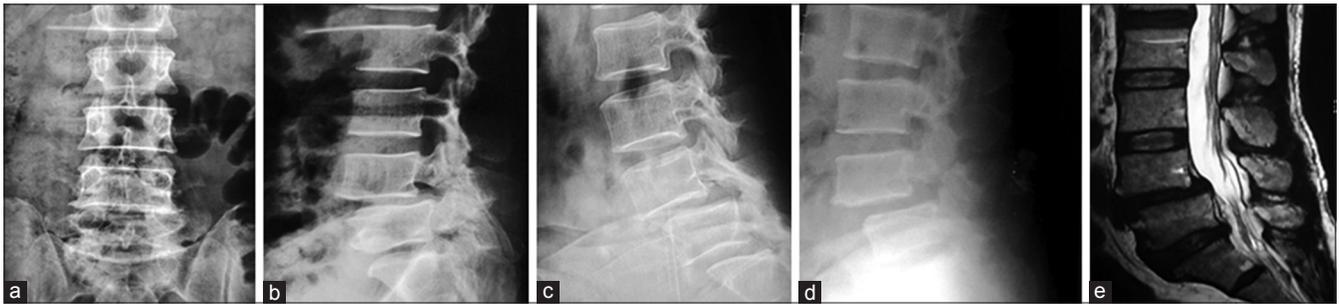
Degenerative instability managed by PLIF; (a) X-Ray lumbosacral (L/S) spine Anteroposterior view. (b) X-Ray L/S spine lateral view showing degenerative spondylolisthesis at L_4 over L_5 . (c) Dynamic film in flexion showing anterior translation and angular displacement. (d) Dynamic film in extension showing differences in translation and angular motion. (e) T2W MRI scan of that patient with degeneration and spondylolisthesis at $L_{4/5}$ level.
